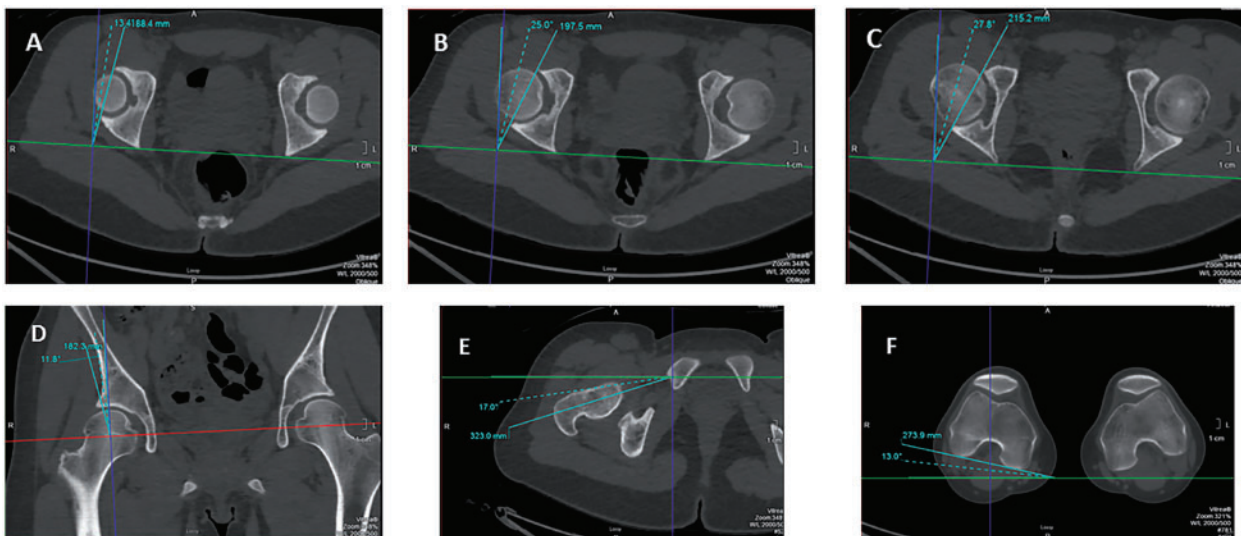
Individual CT cuts of a 28-year-old woman demonstrating how measurements are obtained. Axial cut of right hip measuring acetabular version at the (A) 1 o'clock position, (B) 2 o'clock position, (C) 3 o'clock position. (D) Coronal cut of right hip measuring CEA, (E) axial cut of femoral neck and (F) distal femur—by combining the measurements from E and F, femoral version is determined.
